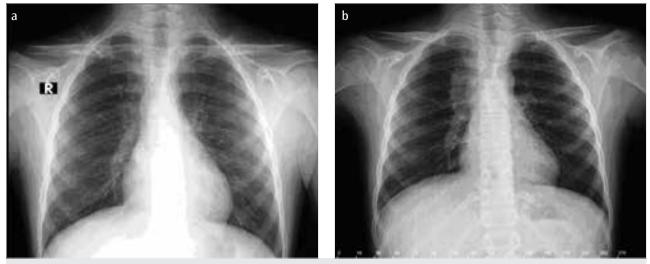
a, b. PA chest radiography findings. (a) Normal PA chest radiography at admission. (b) Paratracheal opacity in the third month of treatment
